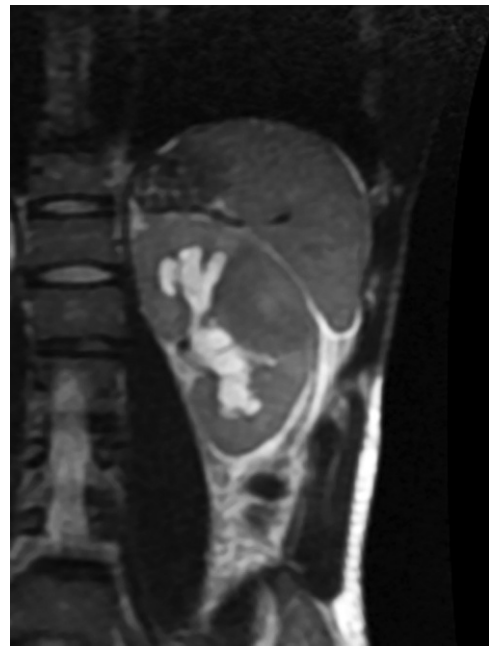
Single shot fast spin echo MRI of the left kidney demonstrates the hydronephrosis as well as the focal region of the decreased signal intensity noted in the mid pole of the left kidney.
